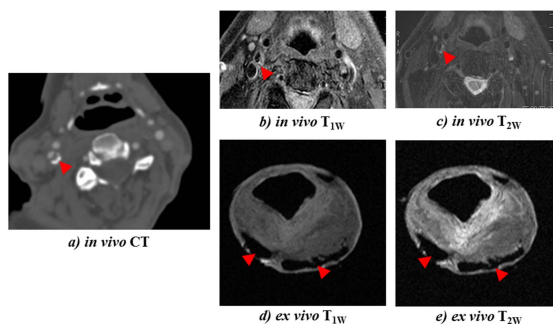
Multimodal matching between a selected slice obtained on patient using CT (a), 3T MRI (b and c) scanners and the closest *ex vivo* slice obtained at 9.4T MRI scanner (d and e)
